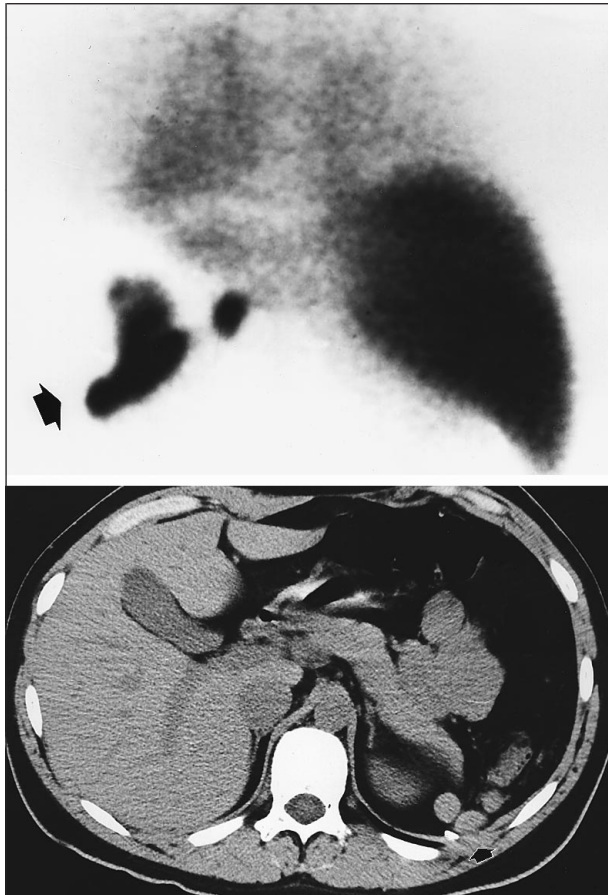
Case 2. A 16-year-old boy with idiopathic thrombocytopenic purpura converted to open surgery because of difficulty in handling the spleen. The spleen weighed 175 g, and the operative time was 240 minutes. The platelet count after 37 months of follow-up was $100 \times 10^9/L$. Top, Scintigraphy shows technetium Tc 99m sodium pertechnetate heat-damaged red blood cell uptake in several areas (arrow) of splenic fossa. Bottom, A computed tomographic scan showing multiple images compatible with residual splenic tissue.
